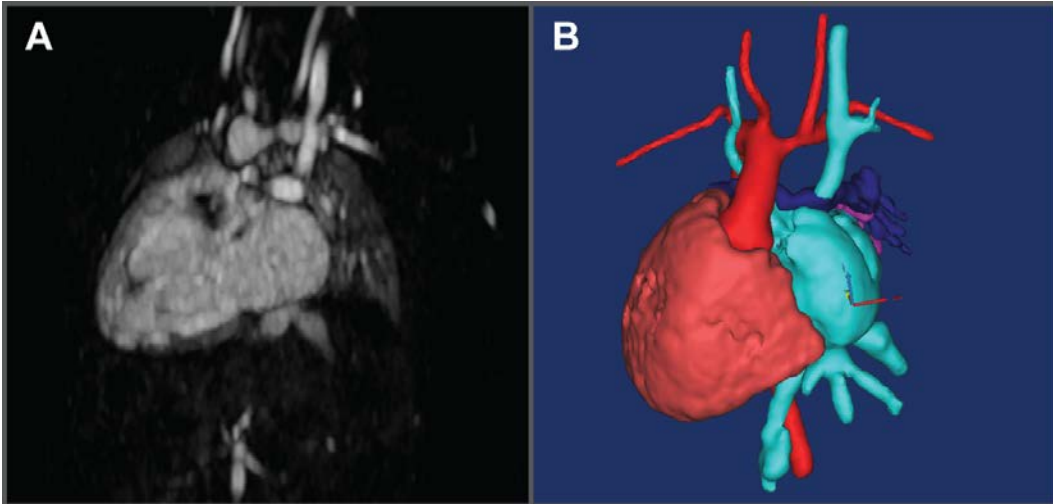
The reduced spatial resolution of an MRI image results in a blurry picture. The reconstruction from this acquisition results in a “smooth” geometric representation.
